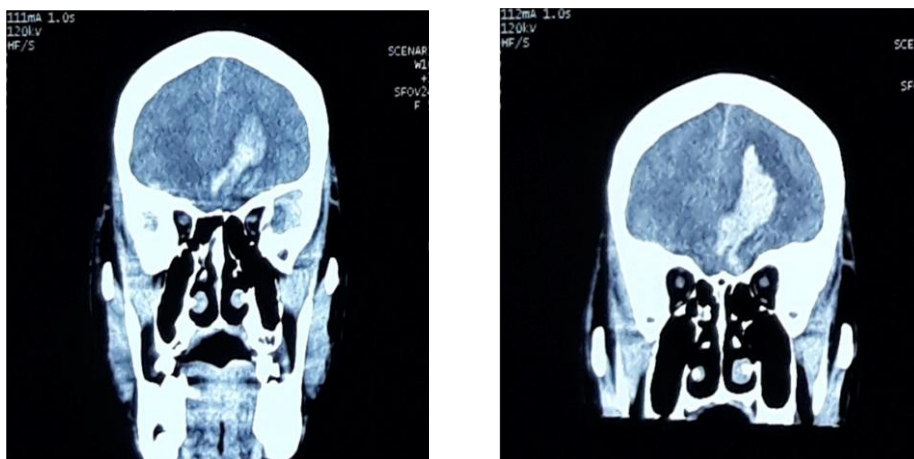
A coronal pre-operative CT scan show multiple contusions at left-right frontal region and enlargement of intracerebral hemorrhage (ICH) at left frontal region.
